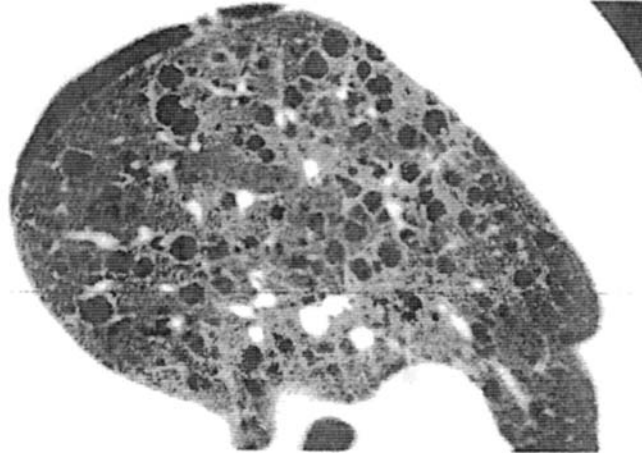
Lymphangioleiomyomatosis. CT demonstrates multiple, thin-walled cystic radiolucencies throughout lung parenchyma. Note small associated pneumothorax, a typical finding in LAM. (Reproduced with permission. From Ref. 85.)
